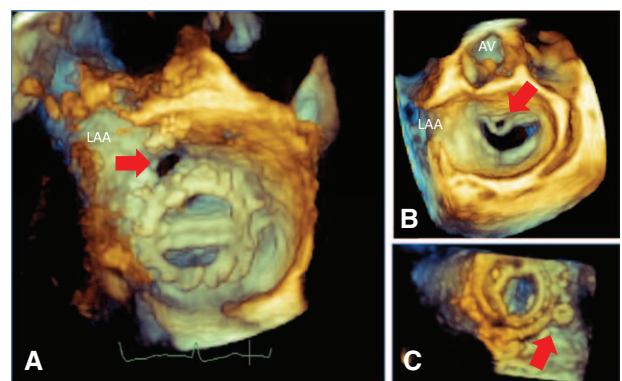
Examples of paravalvular and valvular regurgitation and percutaneous treatment. Three-dimensional transesophageal echocardiographic image of a bileaflet mechanical mitral valve, viewed en face from the left atrial perspective with the aortic valve located at the 12 o'clock position, demonstrating a paravalvular leak (red arrow, A). Three-dimensional transesophageal echocardiographic image of the mitral valve viewed en face from the left atrial perspective demonstrating an anterior leaflet perforation (red arrow, B). Three-dimensional transesophageal echocardiographic image of a tilting leaflet mechanical mitral valve viewed en face from the left atrial perspective demonstrating an occluder device in a paravalvular leak (red arrow, C). AV indicates aortic valve; and LAA, left atrial appendage.
